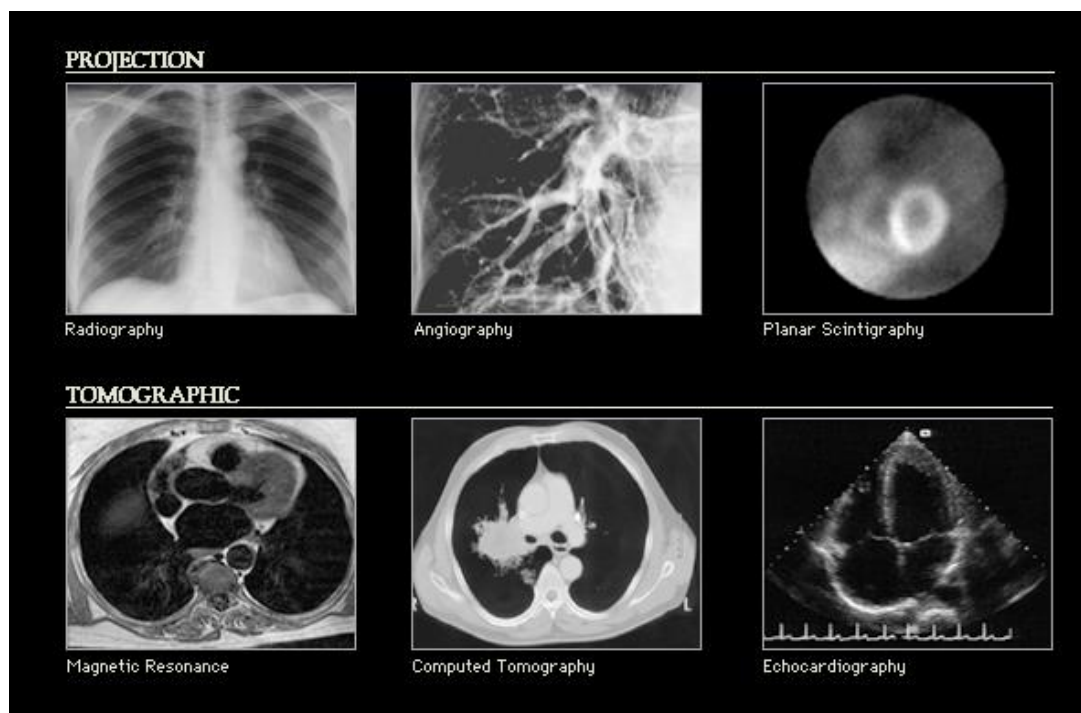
Projection (radiography, angiography, planar scintigraphy) and tomographic (magnetic resonance, computed tomography, echocardiography) techniques (Url-1, 2015).
